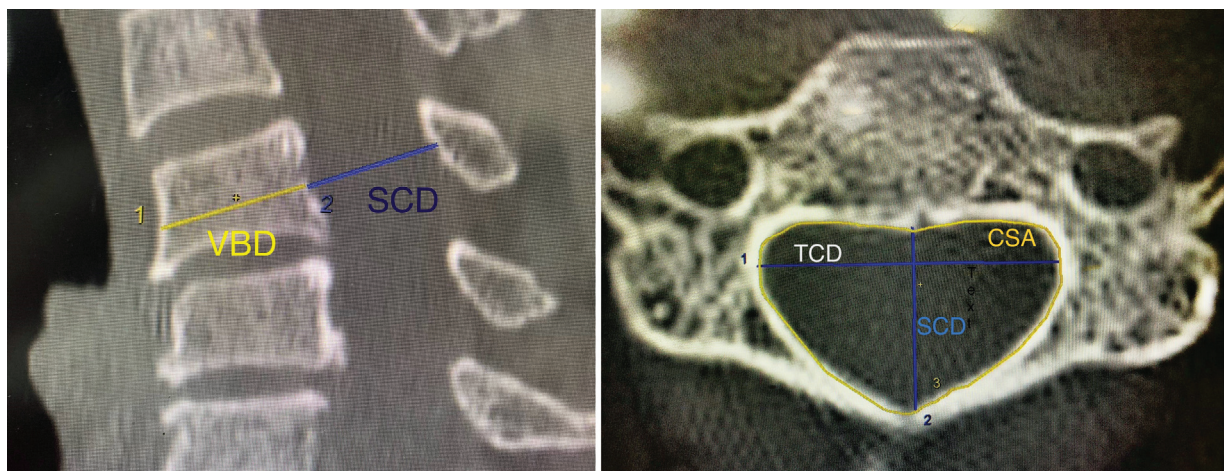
Computed tomography (CT) image of cervical sign showing mid-sagittal anteroposterior diameter, vertebral body diameter, and canal surface area.
